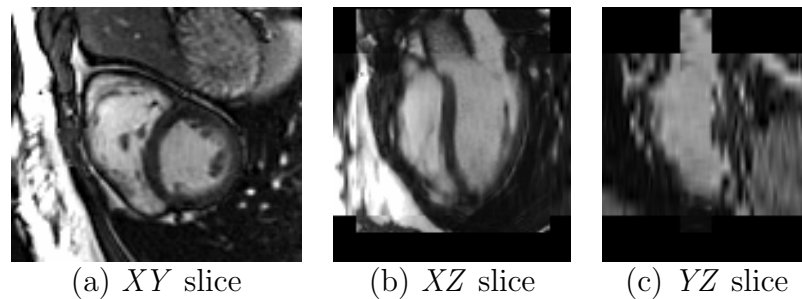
The ‘motion corrected’ and fused image when only two or three long-axis MR images are available.
